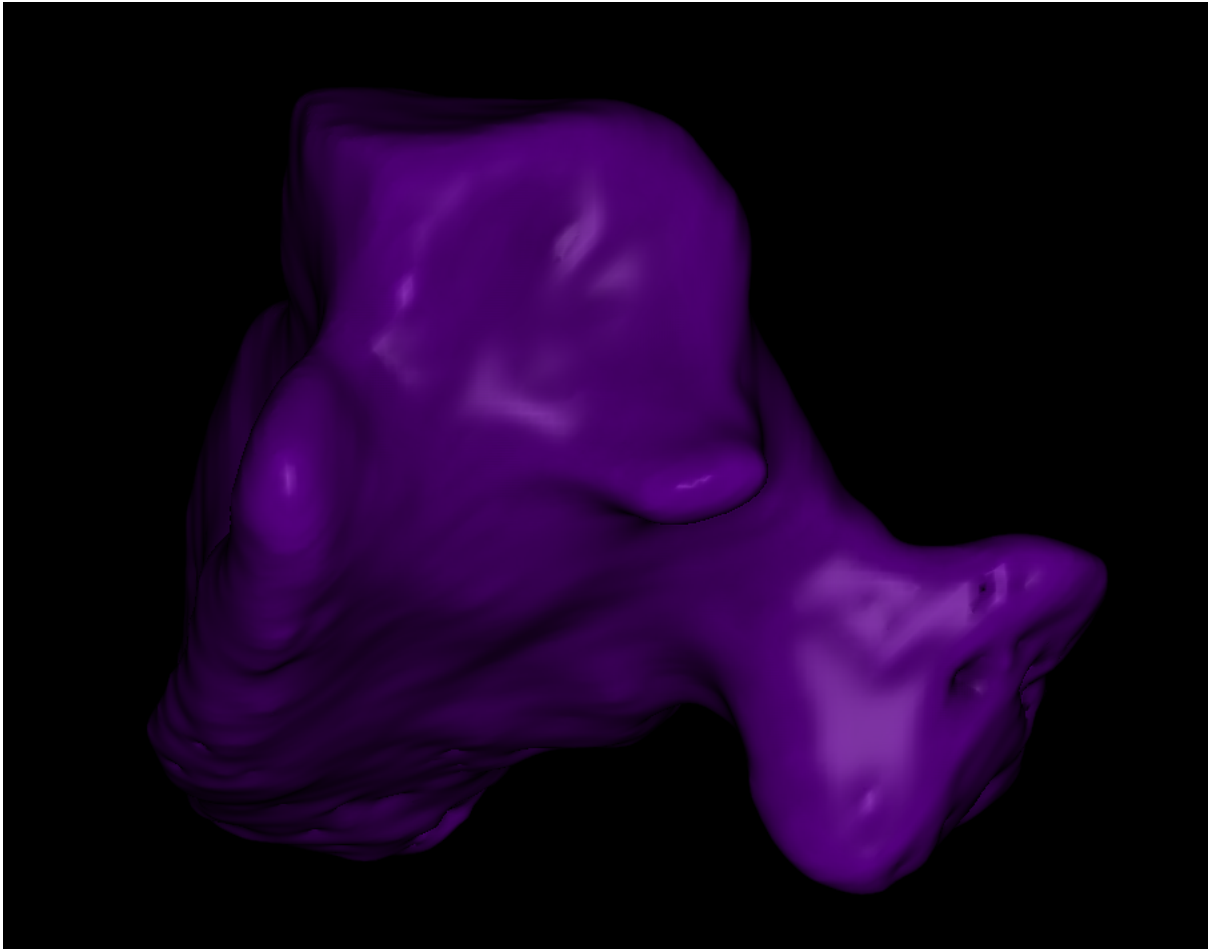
Three-dimensional volumetric image of a left sphenoid sinus, obtained from a cone-beam computer tomography, using DDS-Pro™ software. Source: Own elaboration
